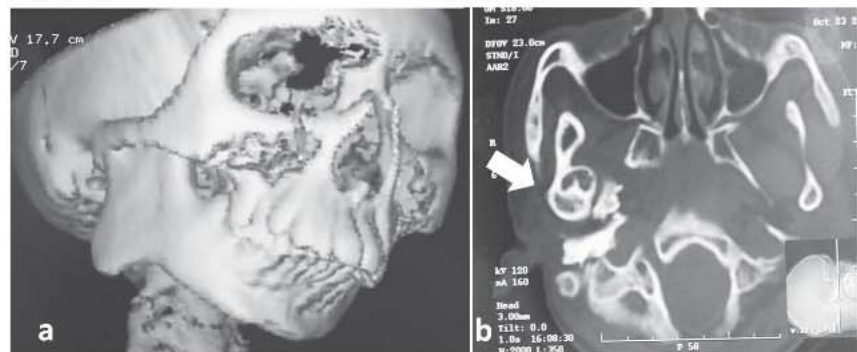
Preoperative Cone Beam Tomogram: a) 3D CT showing complete bony union between the ramus and the glenoid fossa; b) axial view taken at level of TMJ showing complete obliteration of joint space with bony union between condyle-ramus and glenoid fossa (block arrow).
